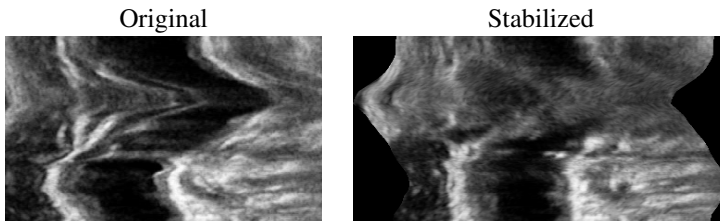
Result of image stabilization. In the original image, the lumen moves in a winding path, likely due to the hand movement of the sonographer. The image stabilization yields a volume with more rectilinear structures. The black regions on the right and left of this image show how the image is shifted to produce a better alignment.
